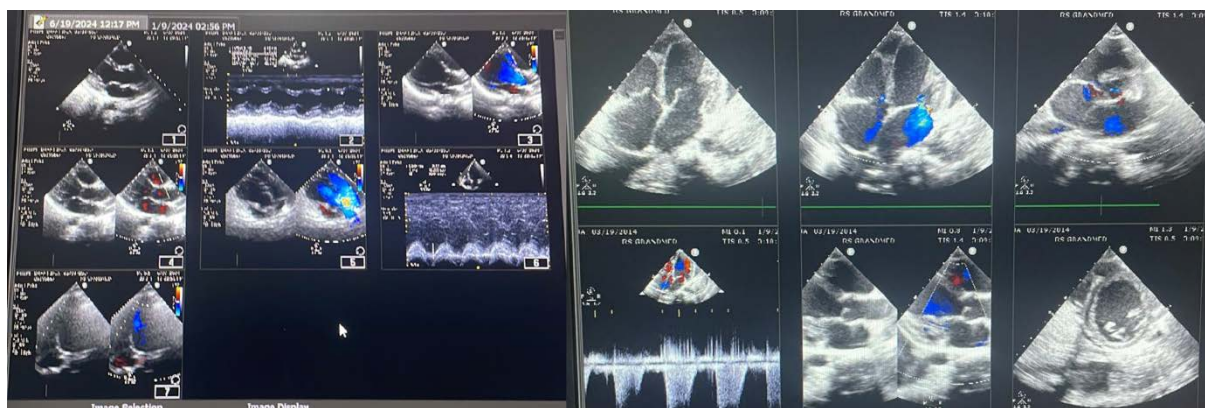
A. Echocardiography on his first day of admission. B. Echo on his 6th months of control after admission
